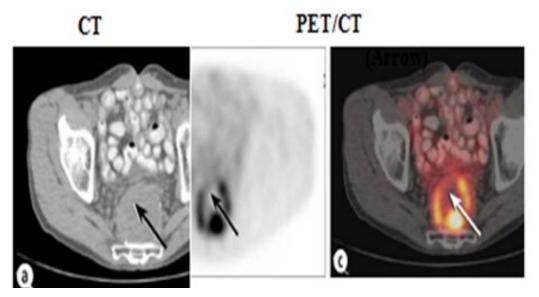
MSCT and PET / CT Recurrent rectal cancer. (a) MSCT shows a large pre-sacral mass that showed negative biopsy. The negative result was obtained because during the puncture the needle passed through necrotic changes in the tumor. (b) The arrow shows the progress of the biopsy image of a fused active tumor with a discontinuous rim surrounding the necrotic center. (c) Repeated biopsy based on PET / CT imaging confirmed tumor recurrence
